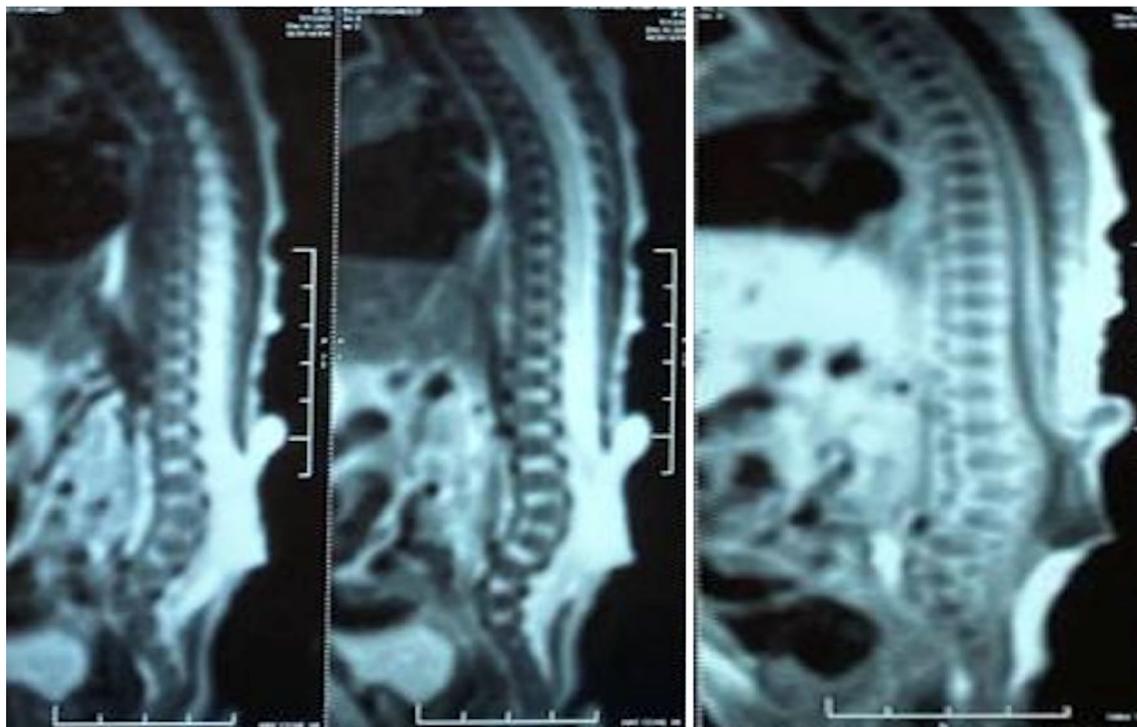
MRI whole spine (sagittal view) showing myelomeningocele
